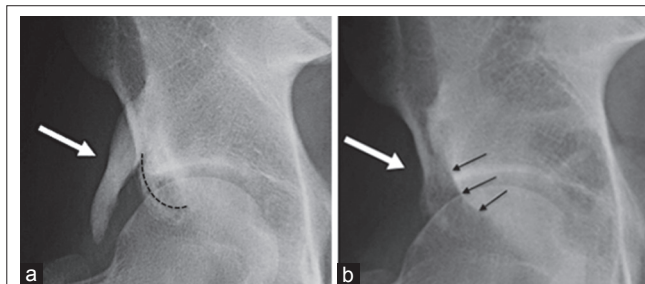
(a) Pre-operative anteroposterior (AP) X-ray image showing large bony exostosis arising from the anterior inferior iliac spine (white arrow) and prominent acetabular rim (black dotted line). (b) AP X-ray image showing complete resection of the exostosis (white arrow) and acetabular rim recession (black arrows) after arthroscopic surgery.
